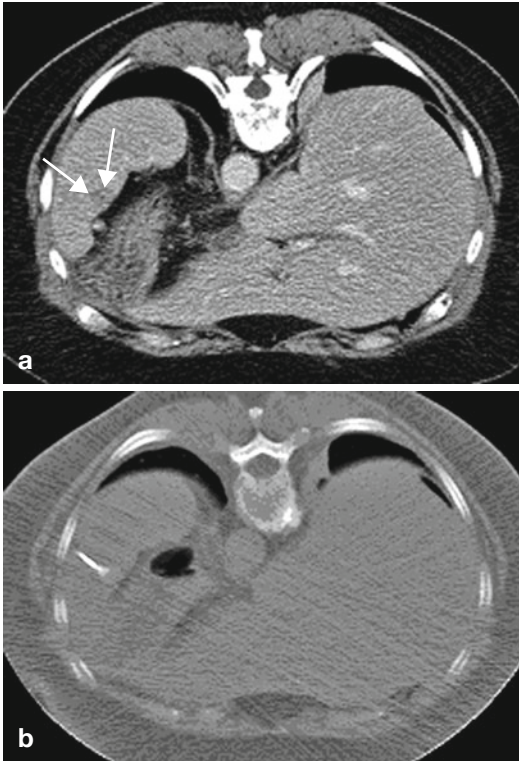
Posterolateral approach to a small metastasis from colorectal cancer located near the splenic hilum with the patient being in the prone position. Preinterventional enhanced CT (a) demonstrates a small focal hypodense lesion within the spleen (arrows). (b) The way to the target in an axial plane with an RF probe opened in the lesion center
